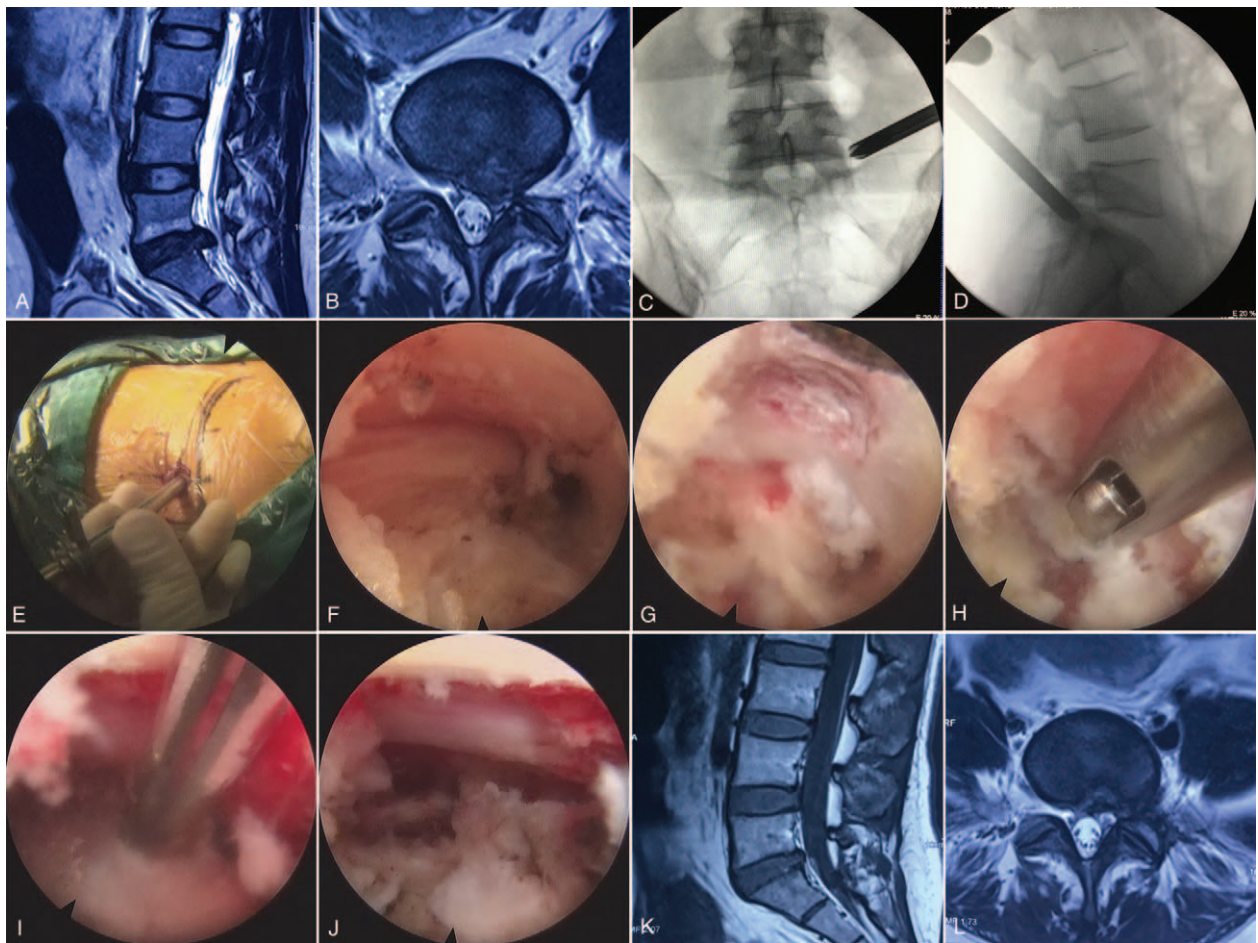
Procedures of the discectomy performed by using full-endoscopic visualization technique via the transforaminal approach on a 36-year-old female patient diagnosed with lumbar disc herniation at L5-S1. (A and B) Preoperative MRI scans; (C and D) intraoperative anteroposterior and lateral fluoroscopy confirm the intervertebral gap and foramina; (E) the surgery is performed under general anesthesia in the prone position; (F) the superior articular process is exposed; (G) foraminoplasty is performed using drills; (H) the herniated nucleus pulposus is extracted; (I) a radiofrequency electrode is applied to control bleeding; (J) the dural sac, traversing nerve root after decompression; (K and L) MRI scans 5 months after the surgery. MRI=magnetic resonance imaging.
